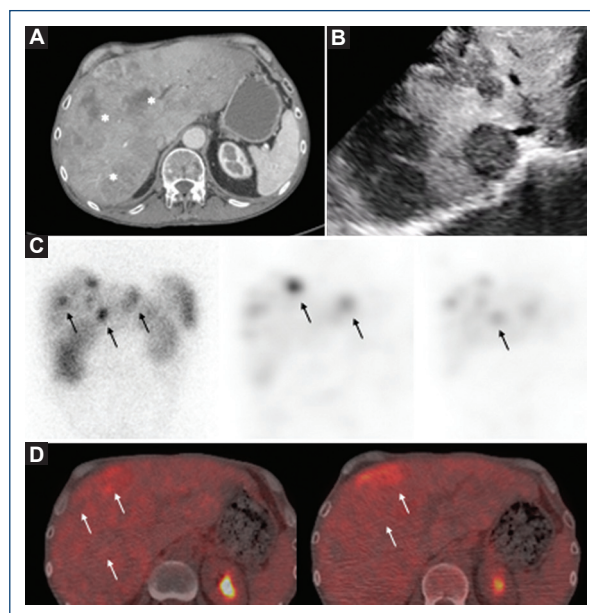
Multimodal imaging metastases. A: computed tomography highlights multiple liver lesions predominantly in the right lobe, with solid aspect and partially confluent that is compatible with liver metastases (asterisks). B: abdominal ultrasound with heterogeneous liver and multiple solid focal lesions. C: scintigraphy reveals multiple active focal deposits of In-111 octreotide in the liver, suggesting the expression of somatostatin receptors in liver metastases (arrows). D: axial positron emission tomography/computed tomography shows most liver metastases without increased metabolism and heterogeneously low ¹⁸F-FDG uptake (arrows).
